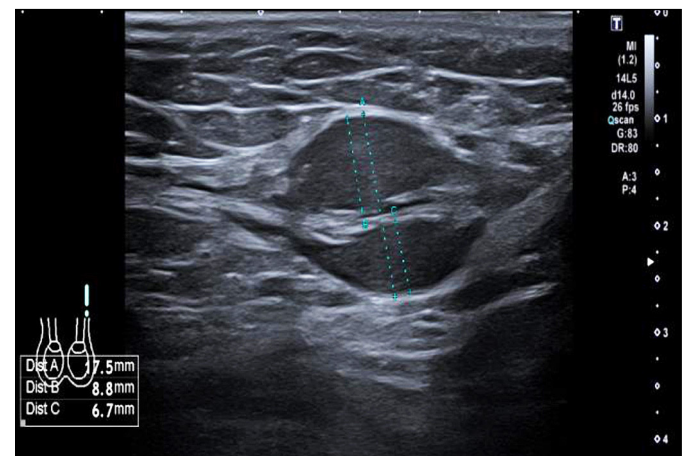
Ultrasound, hypo-echogenic paratesticular structure.
